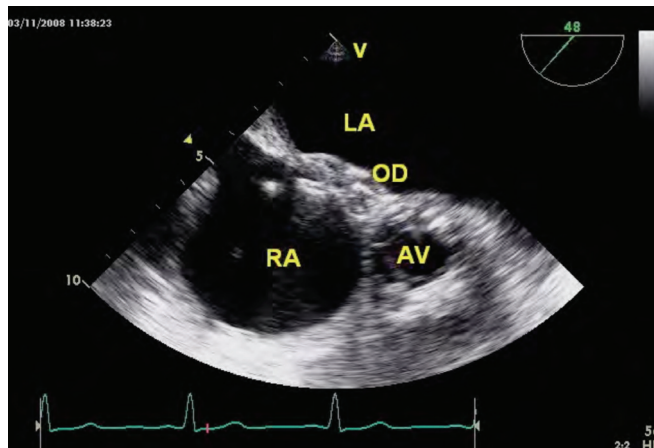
Transesophageal echocardiography image (midesophageal view) showing a secundum atrial septal defect closed with an Amplatzer occluder device (OD) and an opened implanted Edwards SAPIEN aortic valve (AV) in midsystole. LA indicates left atrium; RA, right atrium.
